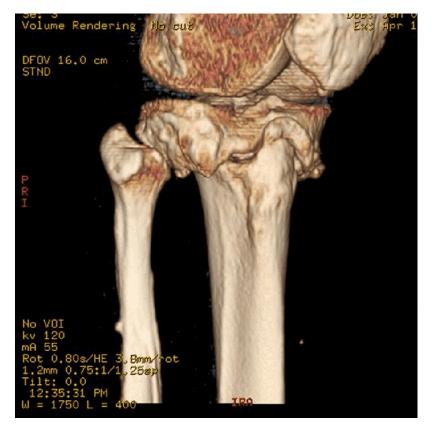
Preop three dimensional computed tomography images demonstrate non-union at the osteotomy site.
